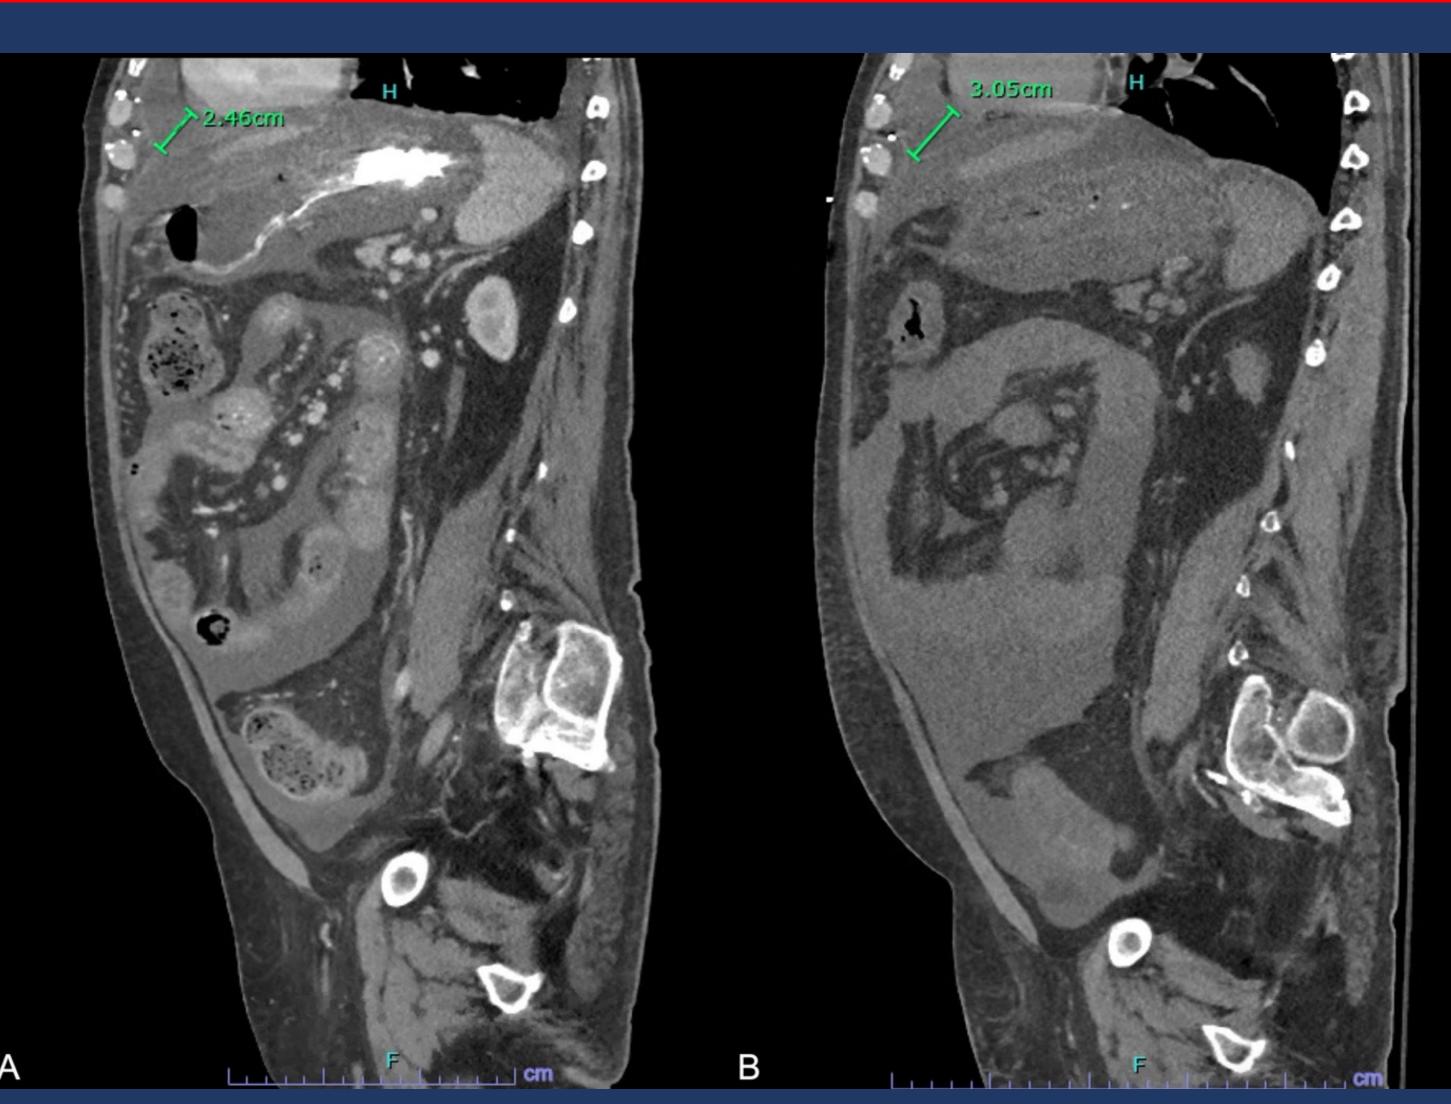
A) Sagittal CT demonstrating pericardial effusion prior to pericardiocentesis. B) Sagittal CT demonstrating recurrence of pericardial effusion after pericardiocentesis.
